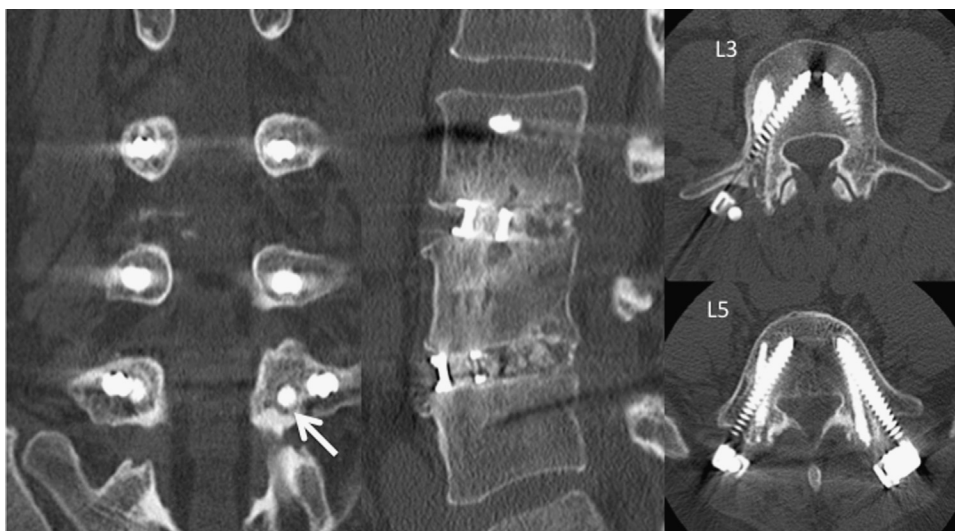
Postoperative CT demonstrating different trajectory pedicle screw replacement at L3 and L5 according to the preoperative plan. The arrow indicates hydroxyapatite granules inserted into the existing pedicle hole.
